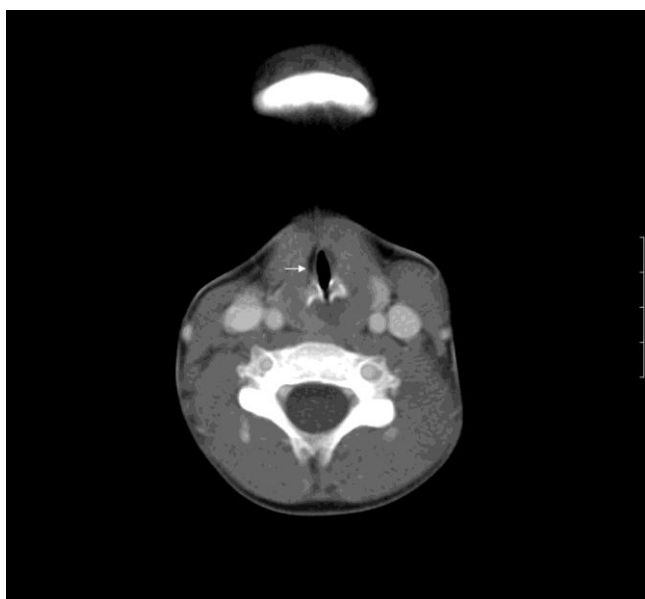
Laryngeal air column is observed to narrow at glottis level on the thoracic CT. Luminal diameter was measured to be 3 mm at this level.
